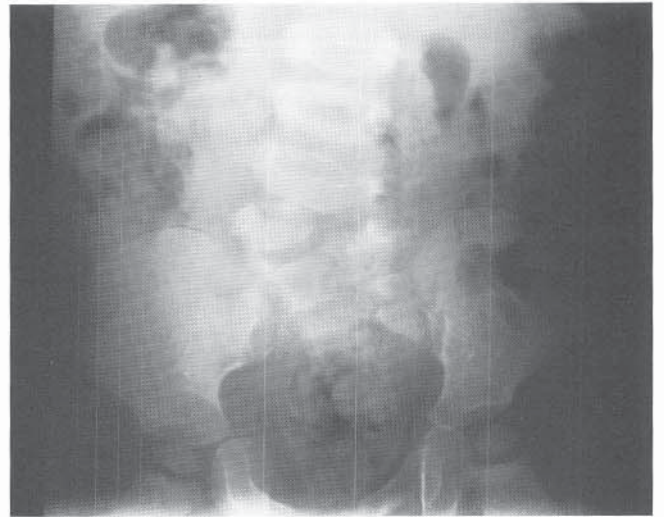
Standing radiograph of an 18-month-old boy showing significant obliquity of the pelvis due to a hemivertebra at the L5 level. Postoperative findings are shown in Figure 11-63.
